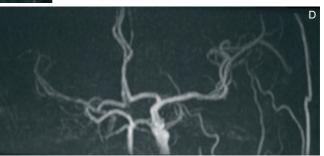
Chronic cerebral ischemic stroke with dystrophic mineralization phenomena (*arrow*) due to cortical laminar necrosis. The lesion appeared hyperintense in T1-weighted images (A, B) and, even in this case, the conventional MRA image (C) is disturbed while the subtractive one (D) not.
